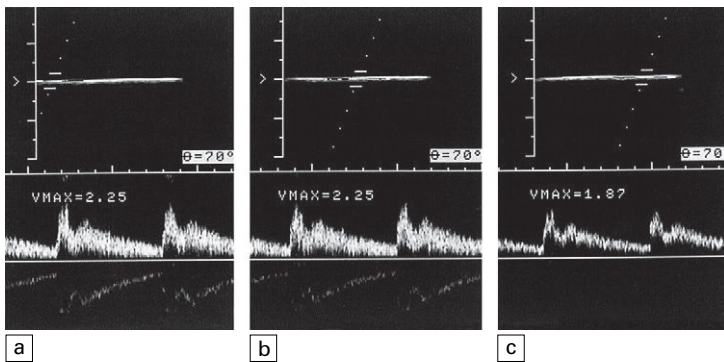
Variation of sonogram for different beam positions in the field of view. A wider aperture is used near the centre of the array to increase focusing. This increases the range of angles of approach of ultrasound and hence increases spectral broadening.
